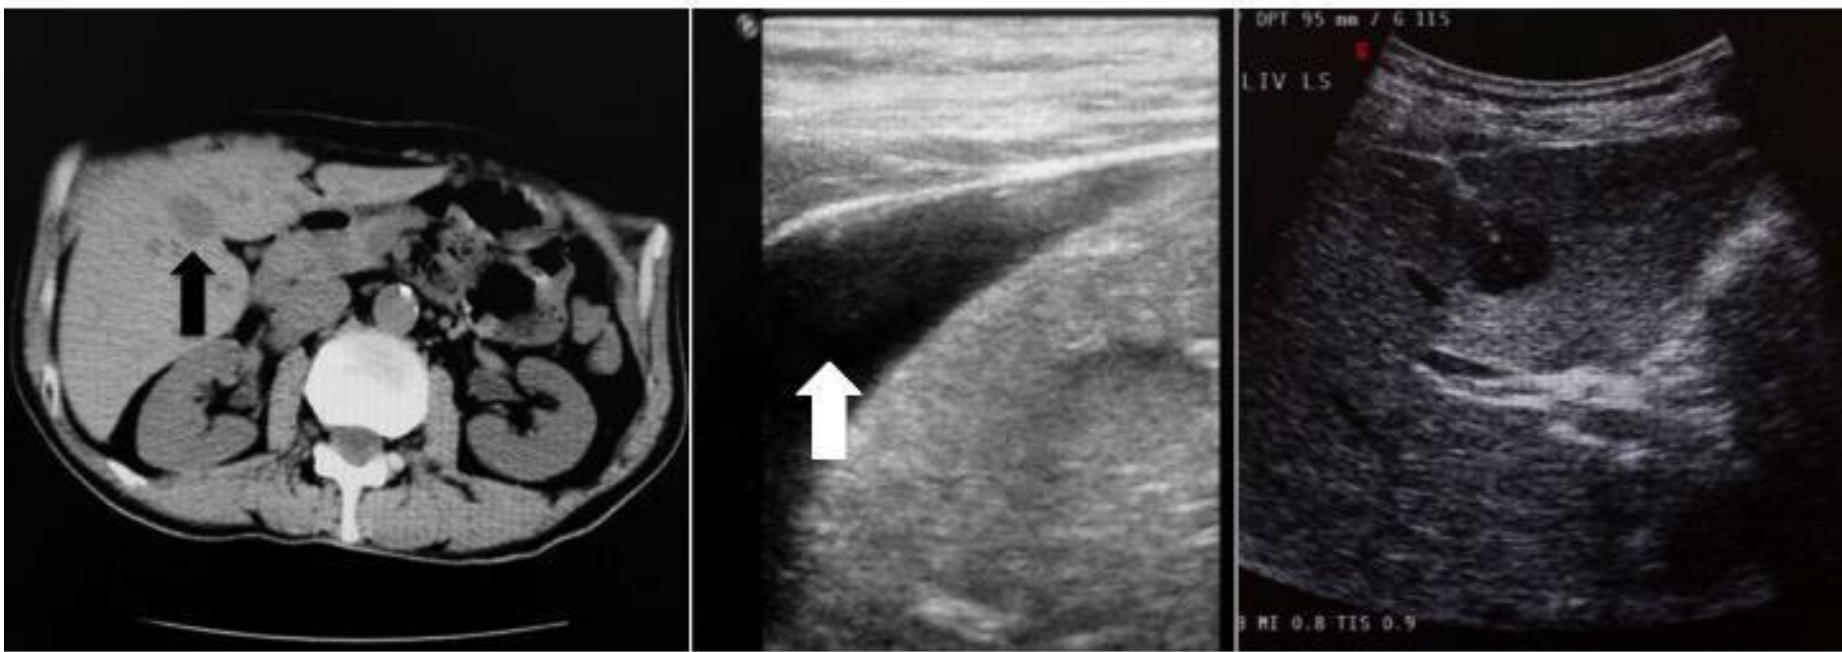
(Left) CT scan showed the presence of solitary liver metastasis (black arrow) measuring 3.2cm in size, located at segment 5 of the liver. (Middle) Before the start of RFA, artificial ascites (white arrow) was created by intra-peritoneal injection of normal saline solution. This was especially important for tumors located in the dome of the liver to prevent collateral damage to the ipsilateral diaphragm. (Right) Afterwards, cooltip RFA needle was inserted under ultrasound guidance. During the delivery of energy, real time ultrasound monitoring was performed.
